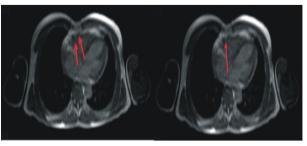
Cardiac MRI of patient showing a dilated and thinned out RV with few small outpouchings (arrows)
